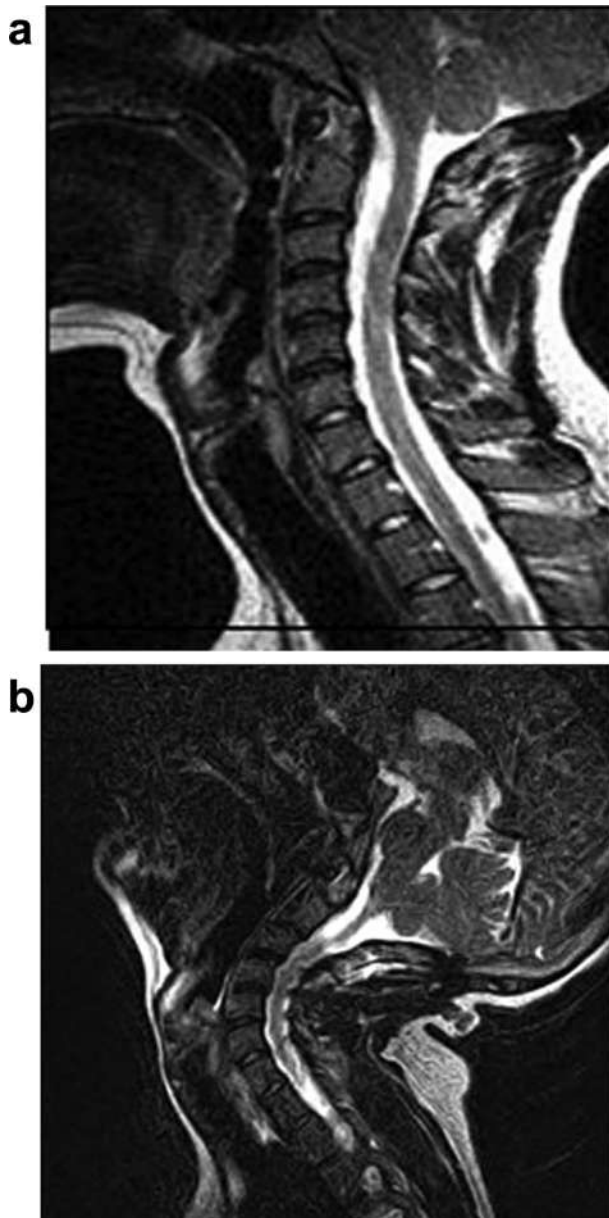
a: Segmental cervical instability, showing widespread degenerative disc disease characteristic of EDS-HT, but no spinal cord compression on neutral view (Sagittal view, T2 weighted MRI of the cervical spine in the neutral position). b: Dynamic instability evident upon extension of the neck, showing postero-listhesis of C4 on C5, causing spinal cord compression (MRI sagittal view of the cervical spine, T2 weighted).
